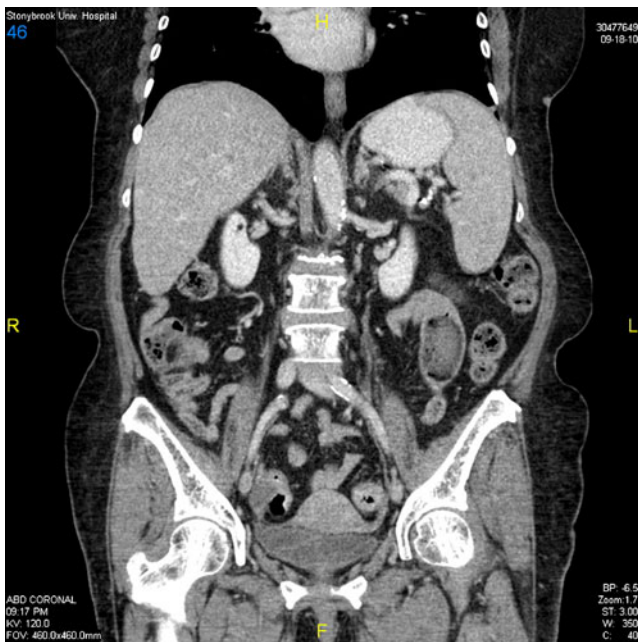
The CT scan revealed dilated loops of jejunum
